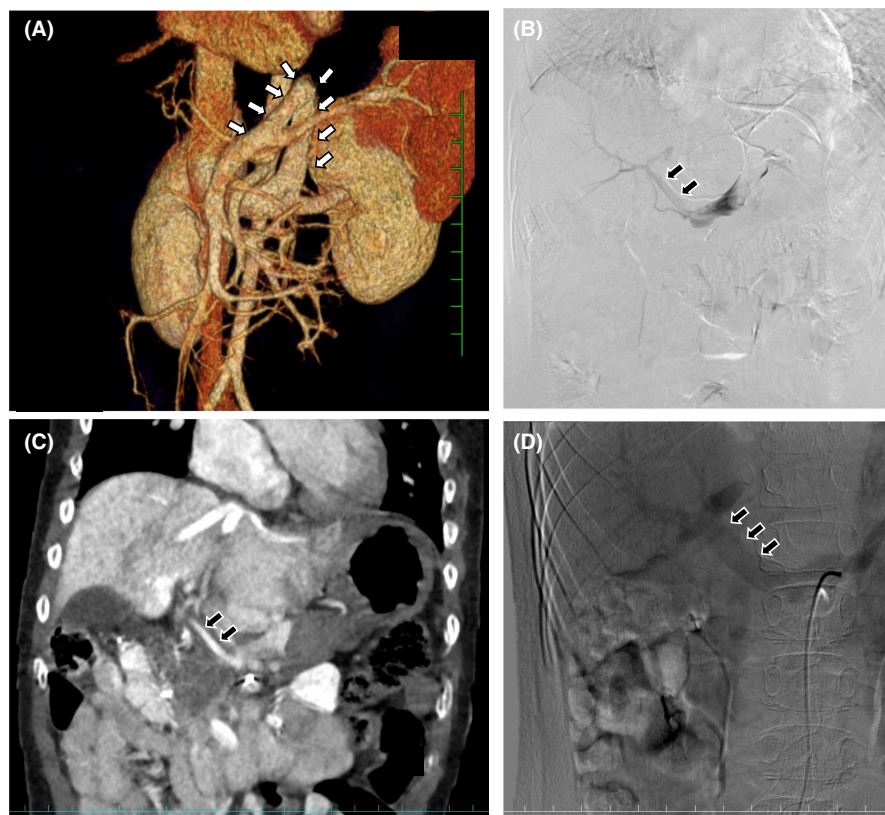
(A) Enhanced computed tomography (CT) revealed that the superior mesenteric and splenic veins were inverted and connected to the left renal vein. (B) Extrahepatic and intrahepatic portal veins were detected in the shunt vessel occlusion test. (C and D) Abdominal enhanced CT and superior mesenteric artery angiography explicitly revealed the portal vein structure after shunt vascular ligation. White arrows, shunt blood vessels; black arrows, portal vein.
